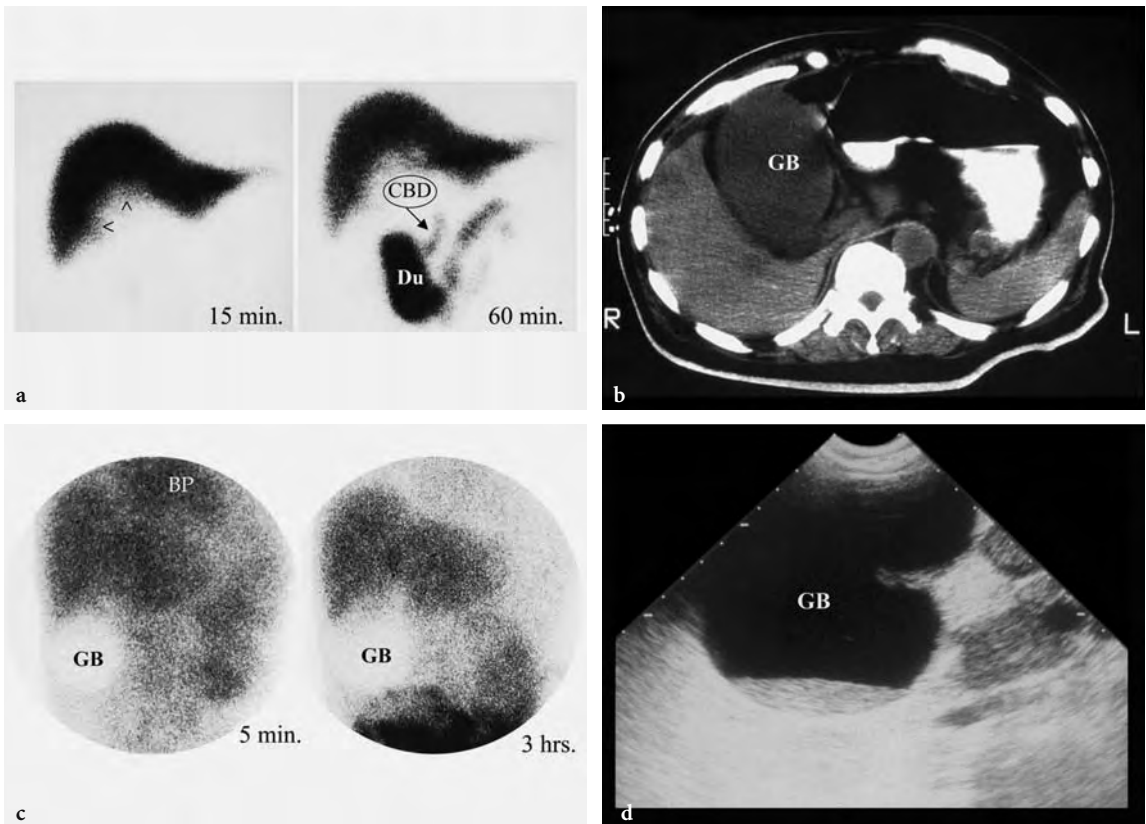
Two examples of bowel activity displacement caused by hydrops gallbladder (GB). a The first case shows an unusually deep rounded indentation at the inferior margin of the liver (*arrowheads*) on the 15-min image. There is an inferomedial displacement of the common bile duct (CBD) and inferior displacement of the duodenal activity (*Du*) on the 60-min image. b CT scan showing a hydrops gallbladder occupying an unusually large area under the liver edge. c A second example depicts hydrops in a form of a photopenic “light-bulb” finding. It did not fill in with radioactive bile at 4- or 24-h images (not shown here). This case also demonstrates poor hepatocellular function in this patient with a cirrhotic liver, reflected in increased cardiac blood pool (BP) and general body background activity. d The ultrasound image demonstrated sludge at the fundus of the hydrops gallbladder
